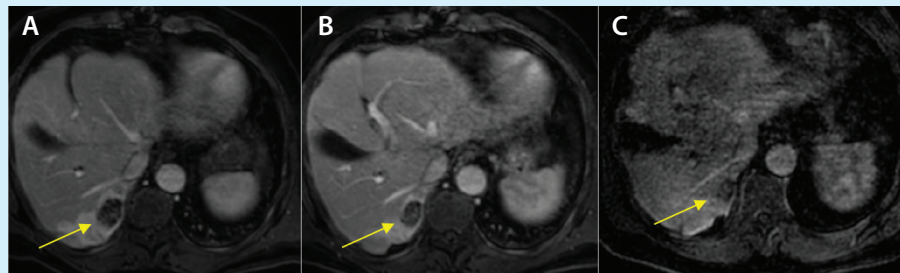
Portal venous-phase, contrast-enhanced MRI taken at 6 (A), 9 (B), and 15 months (C) postprocedure showed lack of tumor enhancement, progressively decreased lesion size, and surrounding segmental atrophy (arrows), consistent with expected changes after radiation segmentectomy.
